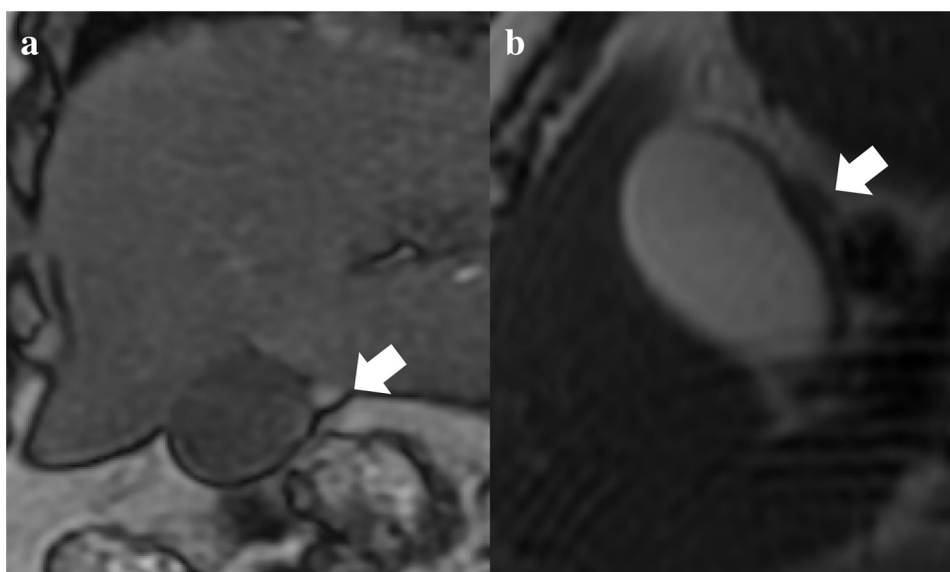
A magnetic resonance imaging (MRI) scan shows the accessory lobe at the surface of gallbladder (arrows): (a) T1WI and (b) T2WI.
